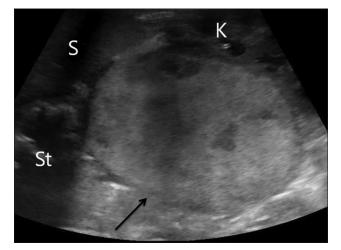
A 1-month-old female infant with neuroblastoma who presented with palpable left upper quadrant abdominal mass. Longitudinal prone sonographic image of the left upper quadrant identifies a round, mixed echogenic suprarenal/adrenal mass (arrow) that abuts the spleen (S) and stomach (St) and displaces the kidney (K).
